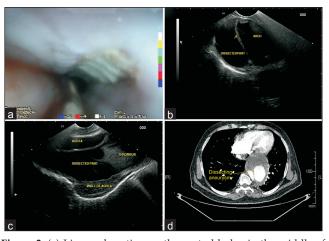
(a) Linear ulceration on the central bulge in the middle of the esophagus (b) EUS image of dissecting aneurysm at the level of arch (c) EUS image of aneurysm with thrombus (d) CT image of the dissecting aneurysm
